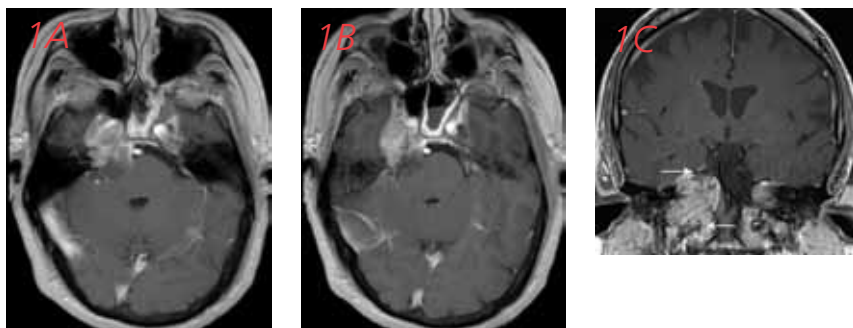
Preoperative T1 magnetic resonance images (MRI) with contrast show a heterogeneously enhancing lesion arising from the right petrous bone extending into the posterior (A) and middle (B) cranial fossa. Coronal views (C) demonstrate the extent of the tumor cranio-caudally (arrows).
